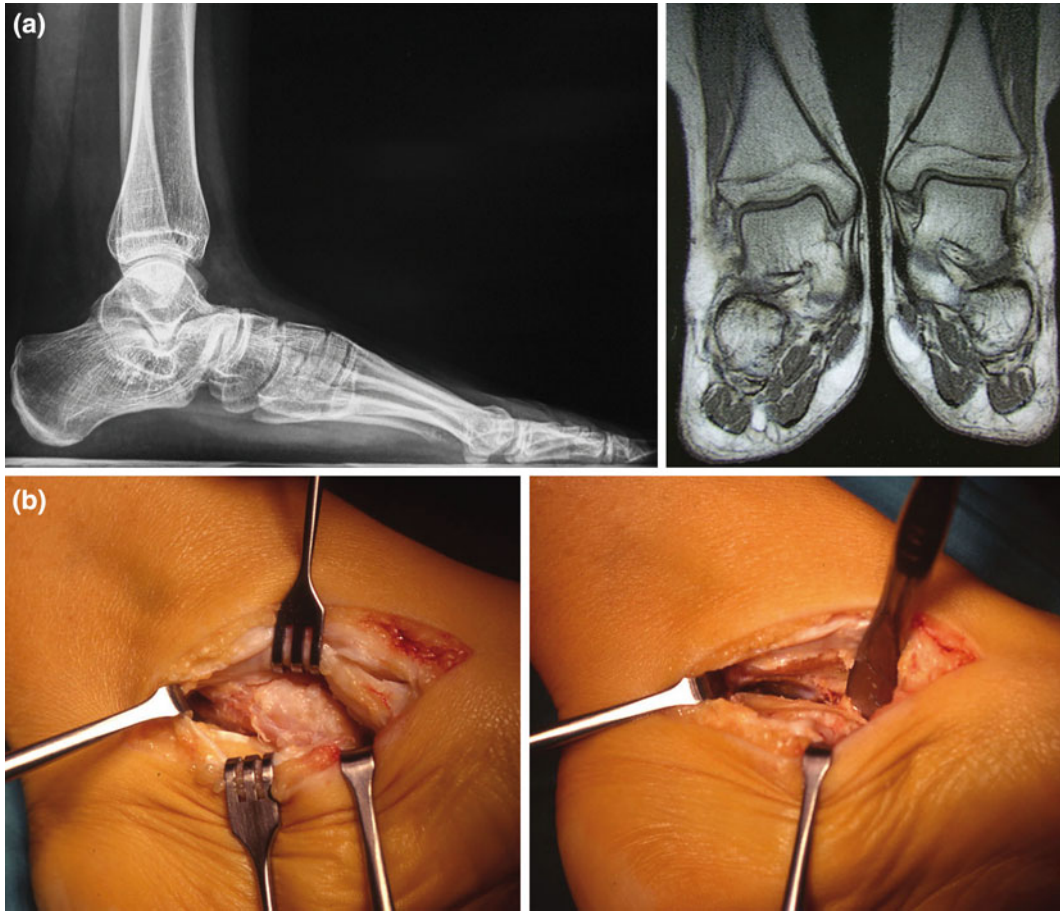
a Weight-bearing lateral X-ray view of *left* foot in a 10-year-old girl with rigid flatfeet. RMN view shows bilateral talocalcaneal coalition. b Intraoperative views of talocalcaneal coalition and its excision
